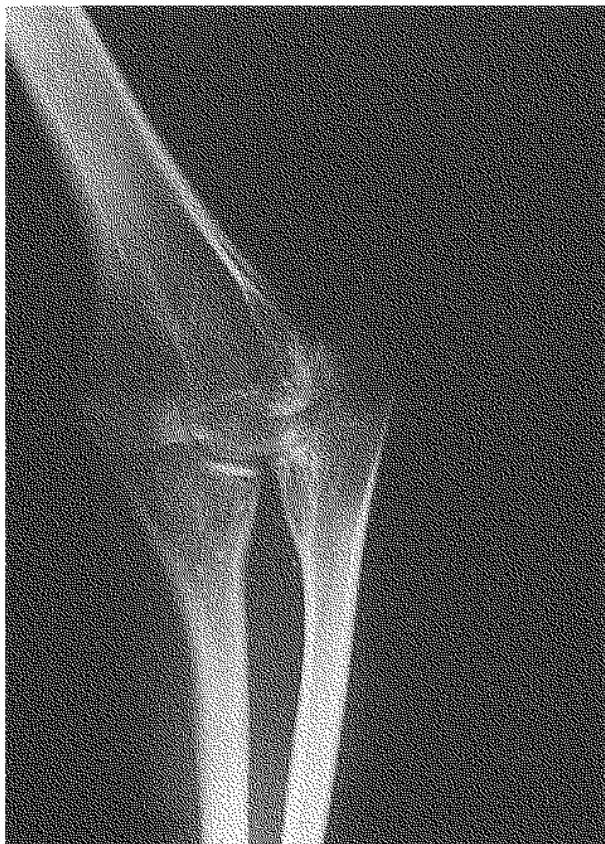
Radiograph of the elbow showing duplication of the ulna and absence of the radius.
